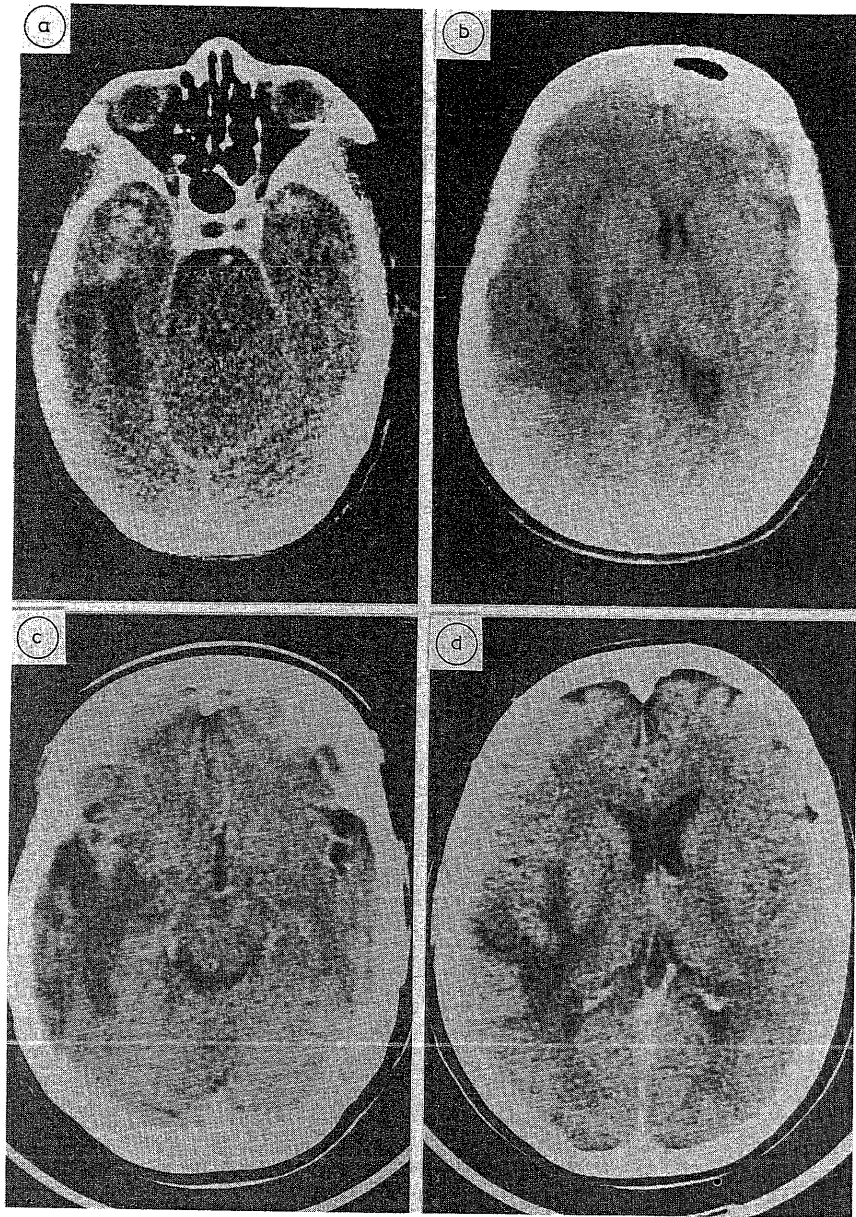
Patient 2. (A, B) Initial CT scan showing a large right temporal hypodense area extending into adjacent portions of the frontal and parietal lobes. There was significant mass effect with midline shift and brain swelling; irregular contrast enhancement was present at the anterior temporal region. (C, D) Follow-up CT scan 27 months later showing a mild decrease in the size of the right temporal hypodense area. Mass effect was much reduced. Contrast enhancement was unchanged.
